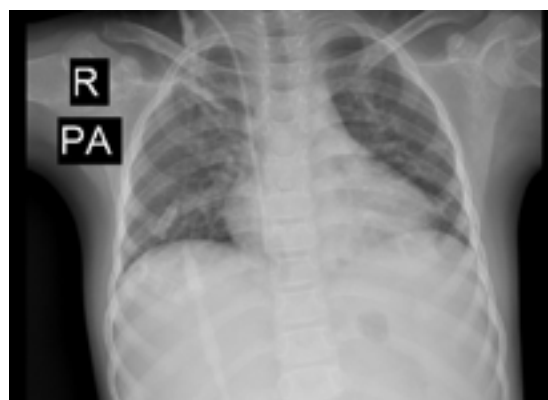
A mild nonspecific reticular pattern in chest X-ray
